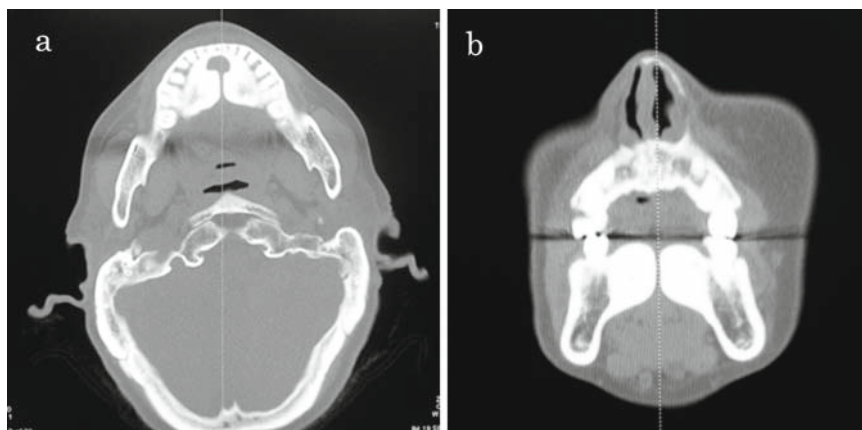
a Axial computed tomography (CT) image demonstrates bilateral mandibular tori arising from the lingual aspects of the second incisor to the first molar regions of the mandibular corpus. b The masses, which overrode the mylohyoid muscles and occupied the floor of the mouth, are shown on a sagittal CT image
